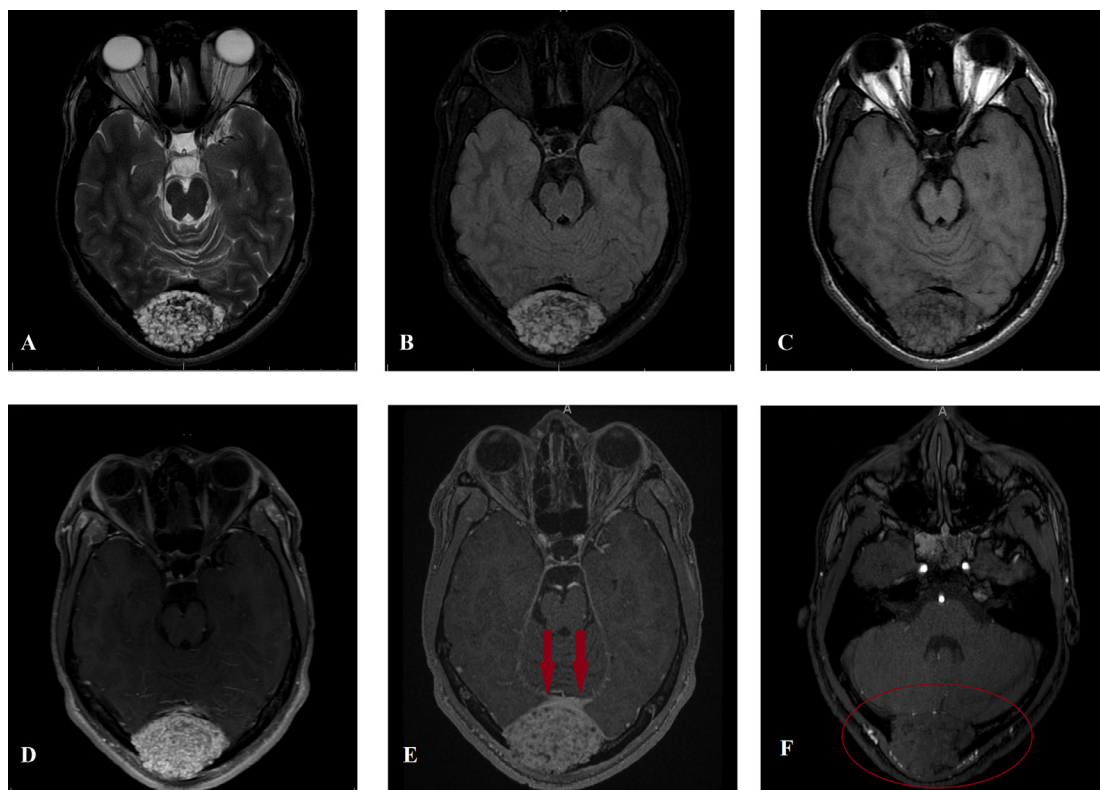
Preoperative work-up. (A) Axial T2-weighted and (B) FLAIR images show a lobular, predominantly hyperintense mass. Axial T1-weighted images (C) before and (D) after IV gadolinium administration show avid enhancement of the mass. (E) Postcontrast axial T1-weighted thin slice image shows mass effect on the adjacent torcular herophili, which is pushed anteriorly (arrows). However, no invasive component or adjacent edema is present. (F) 3D time-of-flight MRA image shows prominent occipital arteries with multiple vessels posterior to the mass. Additional prominent arteries along the anterior surface of the mass intracranially are also noted (circle).
